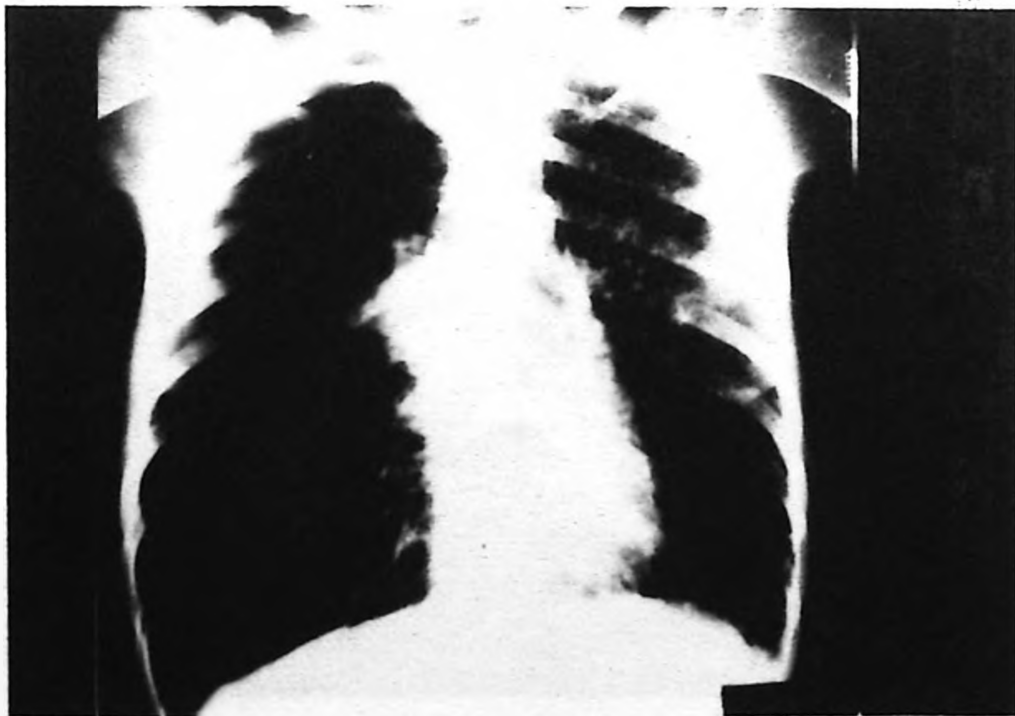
Chest radiograph showing unilateral pneumothorax with typical findings of pulmonary LCH.
